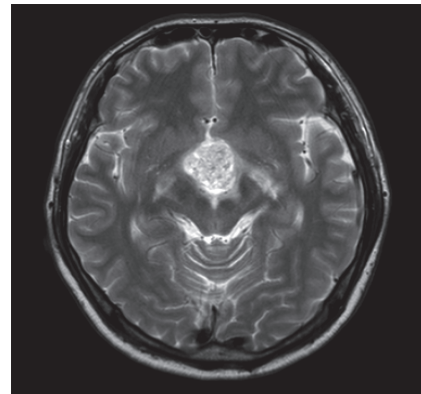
Brain MRI of prior to surgery
